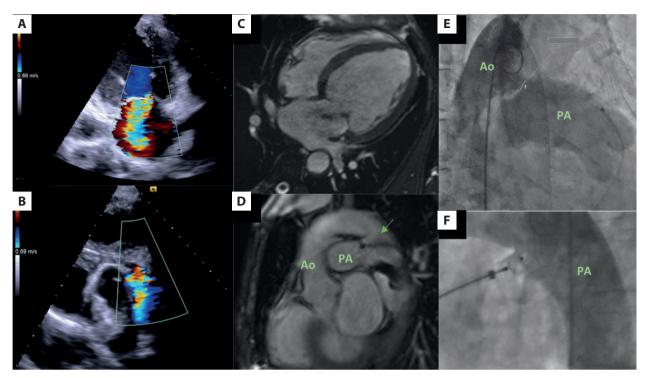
A–B. Transthoracic echocardiogram showed moderate mitral valve regurgitation, which raised the suspicion of a persistent patent ductus arteriosus. C. CMR revealing severe left chamber enlargement. D. CMR confirmed a PDA (10×12 mm) between the left pulmonary artery and the descending aorta, with a Qp:Qs ratio of 2:1. E. Angiographic evaluation confirmed the presence and size of the ductus. F. Percutaneous transcatheter closure of PDA with an Amplatzer device, with no residual shunt
